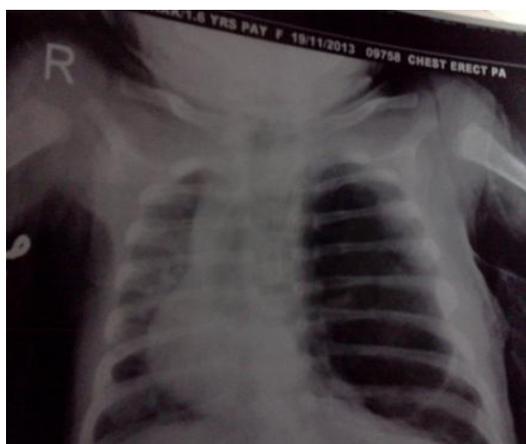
X-ray with large cystic lesion of the left lung
